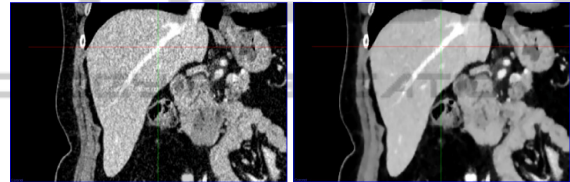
High quality CT and its TV L2 denoising.
